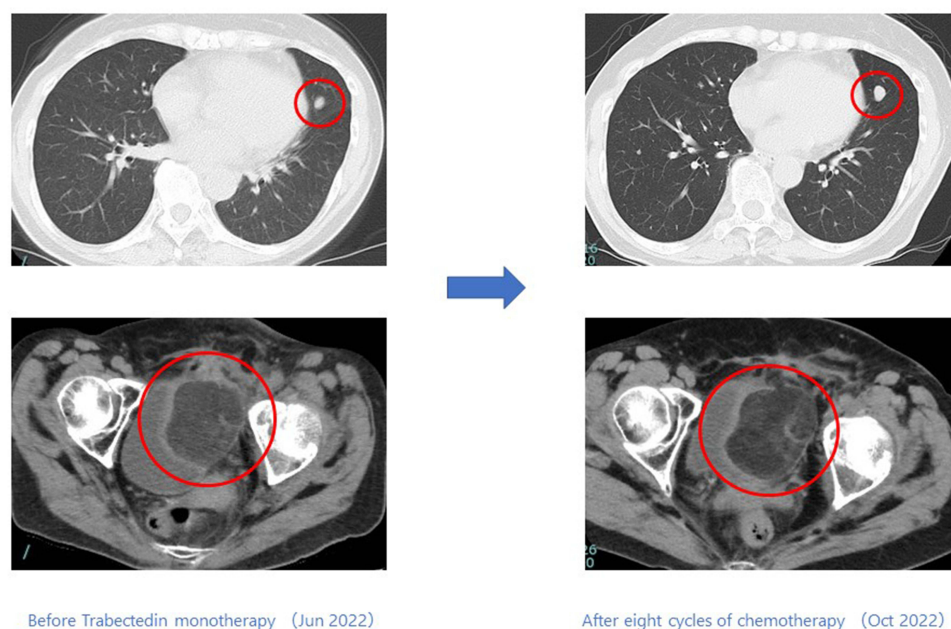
Changes in imaging of Case 3 patient before and after trabectedin administration (Chest and abdominal CT) Metastatic site of lung and primary site of retroperitoneal lesion showed a stable disease with slight increase after eight cycles of trabectedin monotherapy compared to the findings of pre-treatment.
